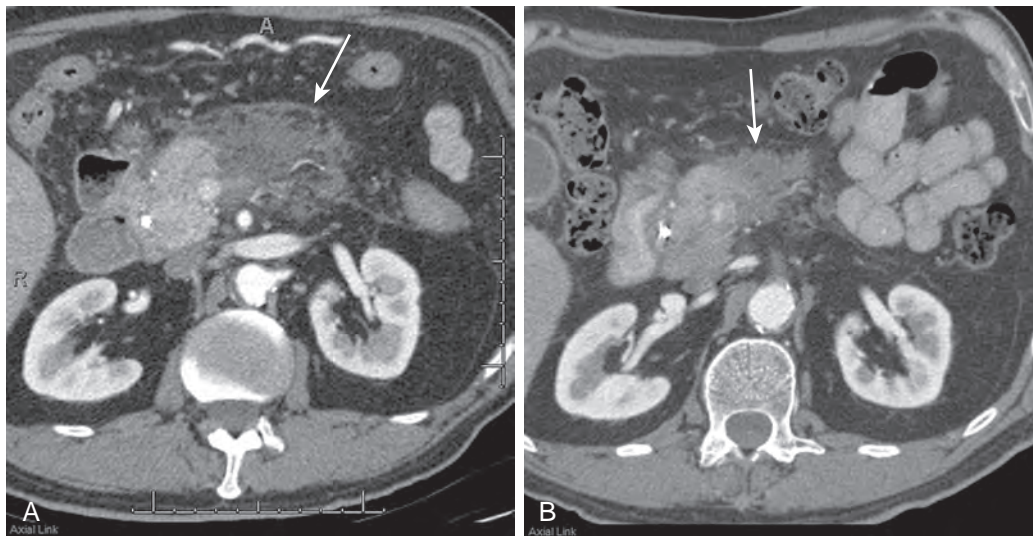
Pancreatitis. A. Axial CT at the time of acute pancreatitis demonstrates hazy soft tissue (arrow) surrounding the pancreas and extending into the root of the mesentery. B. Axial CT obtained 2 months later demonstrates evolution of the changes of pancreatitis with a more solid appearance (arrow).
